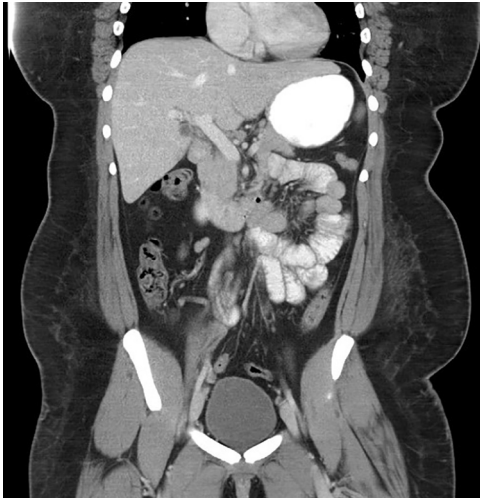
Coronal views of computed tomography scan of abdomen and pelvis with contrast showing a small 9-mm structure in the gallbladder fossa likely related to gallbladder agenesis with no biliary obstruction and normal hepatic anatomy.
